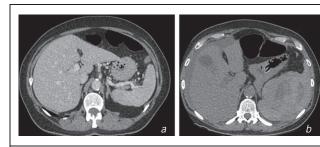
Computed tomography of before (a) and after (b) rupture of the spleen
